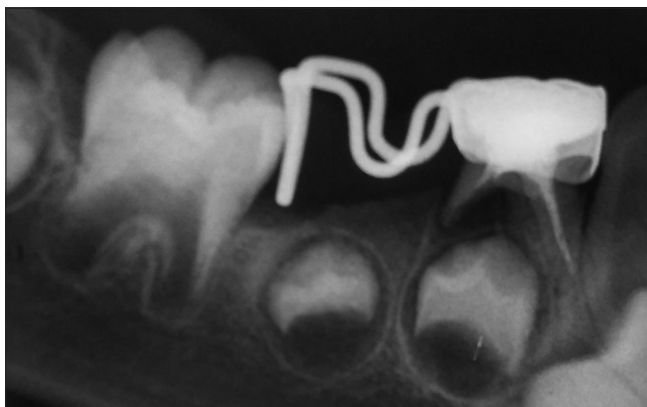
Radiograph taken after the eruption of 46.
